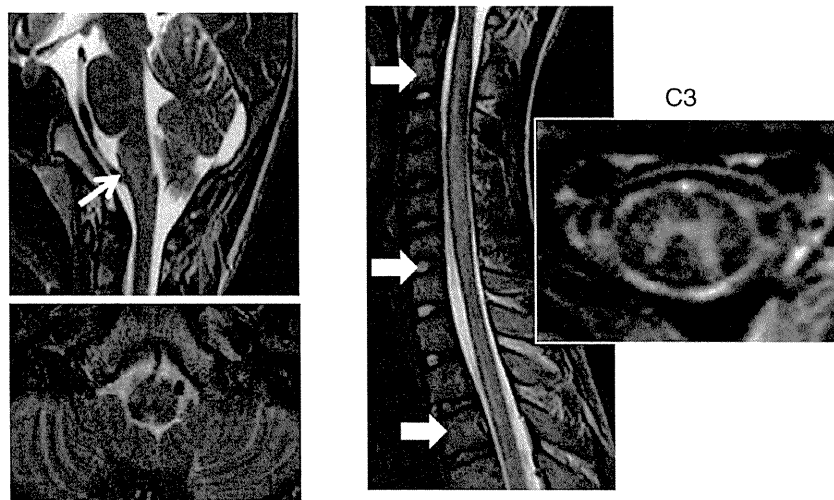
T2-weighted MRI at 7 days from onset: high spinal lesion from C2 to T11, centering on the gray matter and lesions, not continuous with the spinal cord on the ventral side of the medulla.
